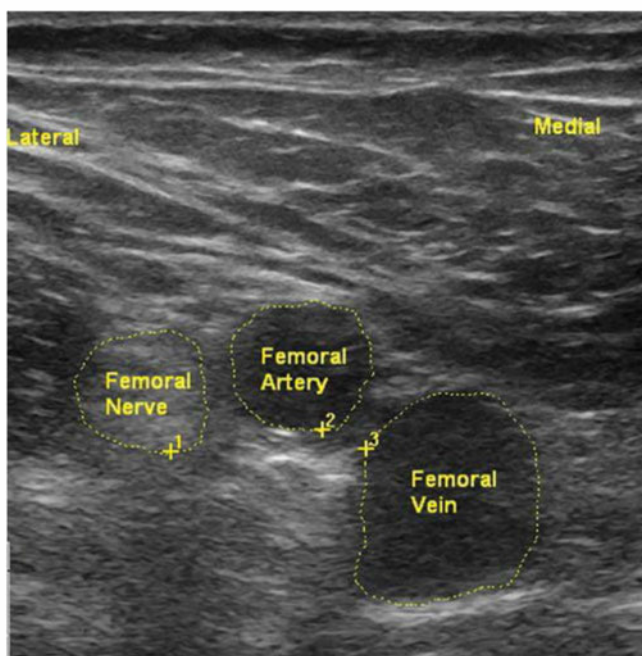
Transverse ultrasound view of the femoral vein anatomy. Structures from lateral to medial: femoral nerve, femoral artery, and the femoral vein.
